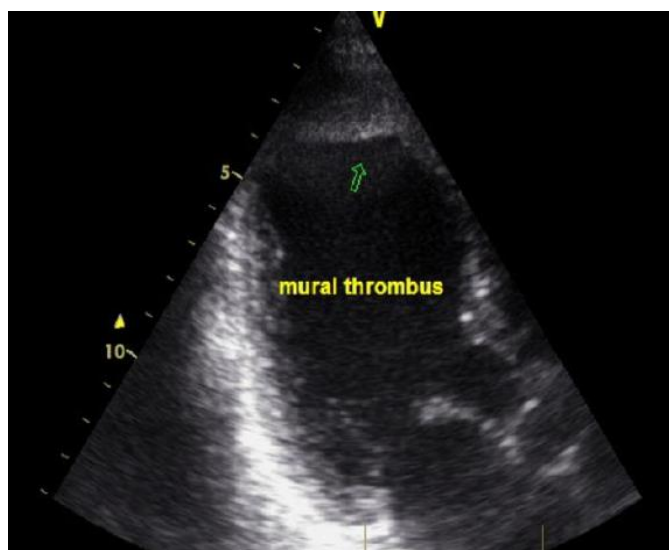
Apical thrombus seen in the apical aneurysm on apical two chamber view
